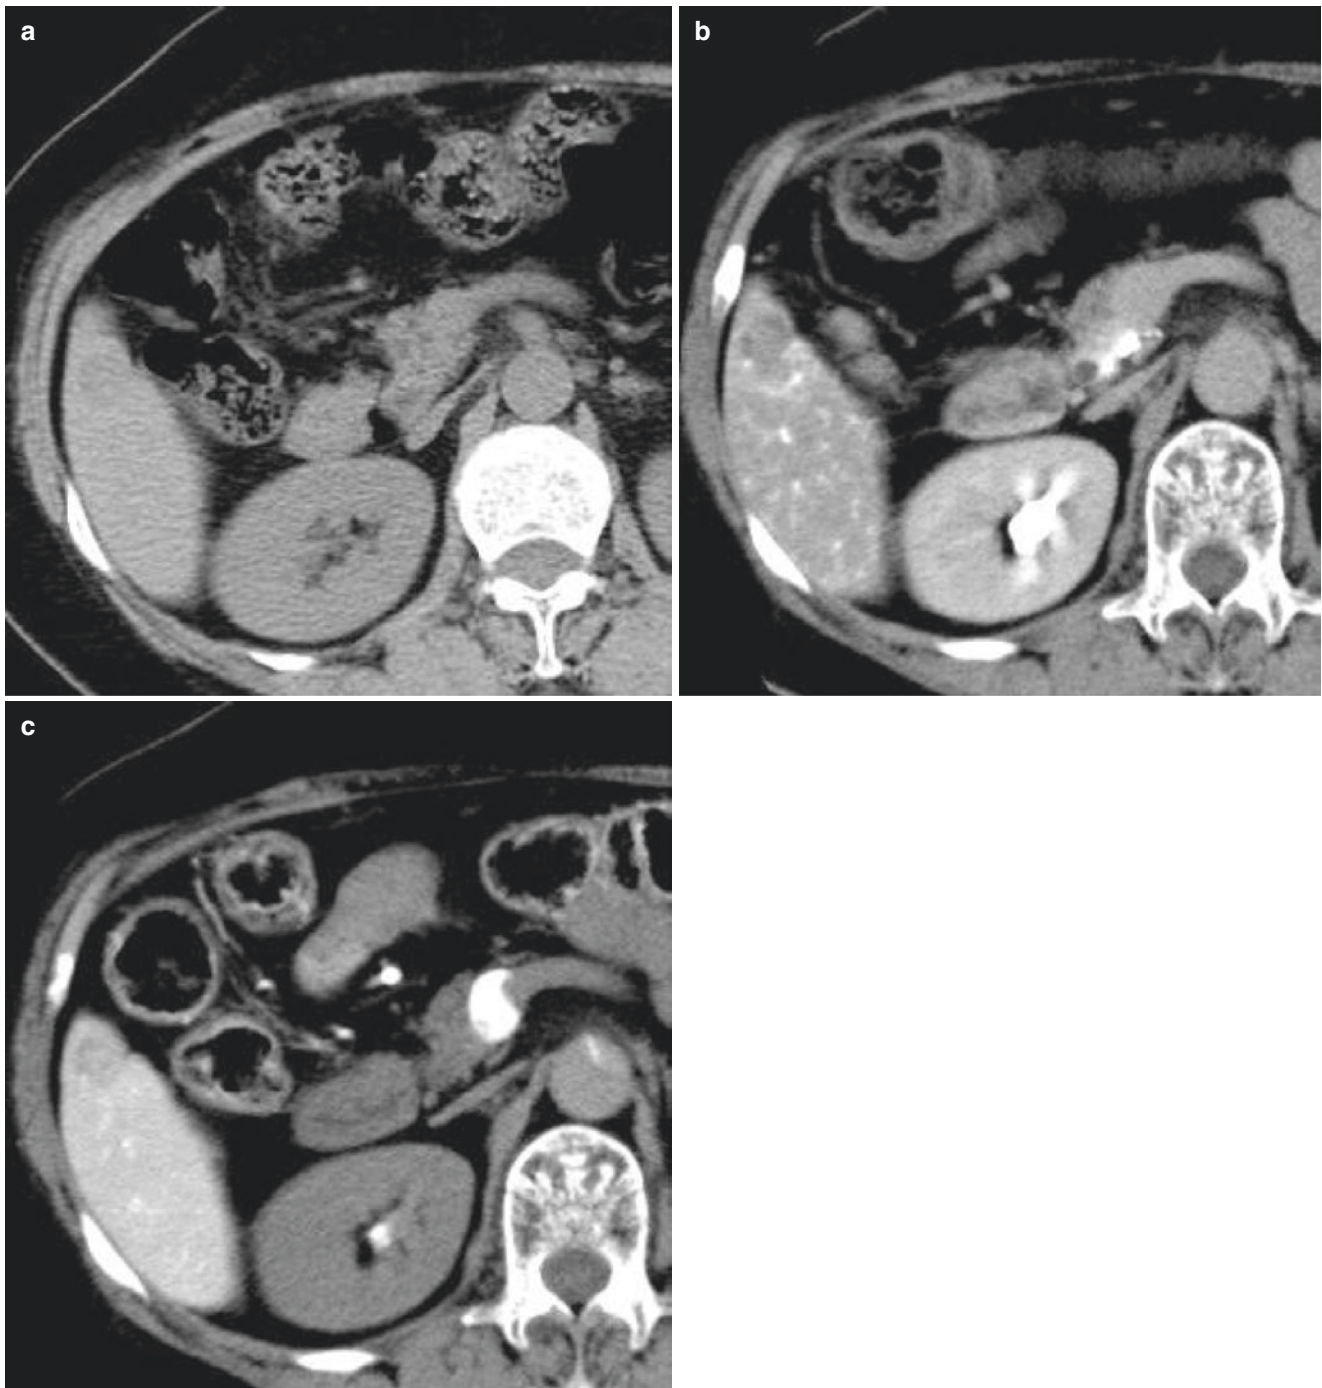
Angio-CT for early HCC. The small low-density nodule is observed in S6 in plain CT image (a). CT arteriography (CTA) revealed the hypovascular tumor (b). CT arterial portography (CTAP) showed decrease of portal flow in the tumor (c)
